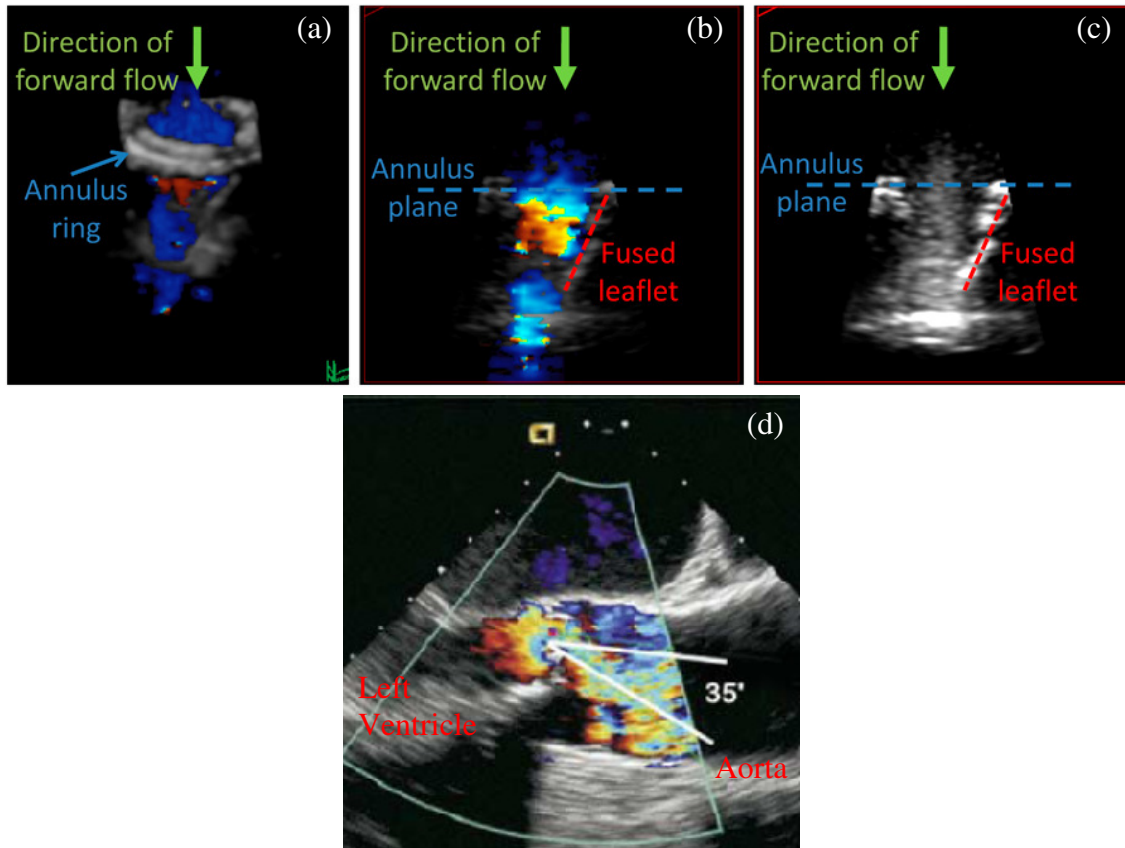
(a-c): Ultrasound images of the BAV model in the in vitro flow loop. (a) 3D B-mode and Color Doppler ultrasound of the valve; (b) 2D B-mode and Color Doppler ultrasound of the valve; (c): 2D B-mode ultrasound of the valve. The fused leaflet is visible in these images, but the non-fused leaflet had faint signals. Color Doppler signals showed that the flow is skewed away from the fused leaflet. (d) Clinical Color Doppler echocardiogram of a stenotic human BAV with eccentric forward flow [119].
